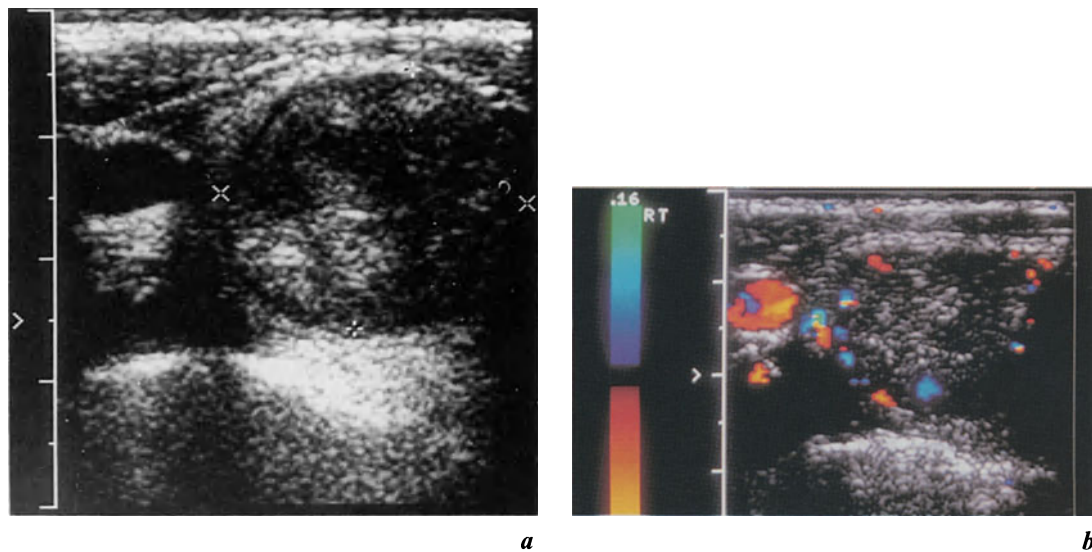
Gray scale ultrasound scan *a* and corresponding CCDS image *b* of a papillary carcinoma in the right thyroid lobe (transverse section, carotid artery shown in red on CCDS image). Note the similarity of the findings to those shown for the adenoma in Fig. 7a, b including a “halo” on the gray scale scan
